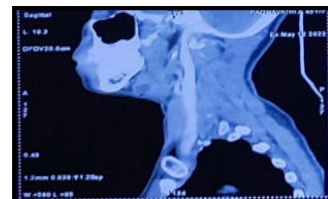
PREOPERATIVE Computed Tomogram of neck sagittal view.
